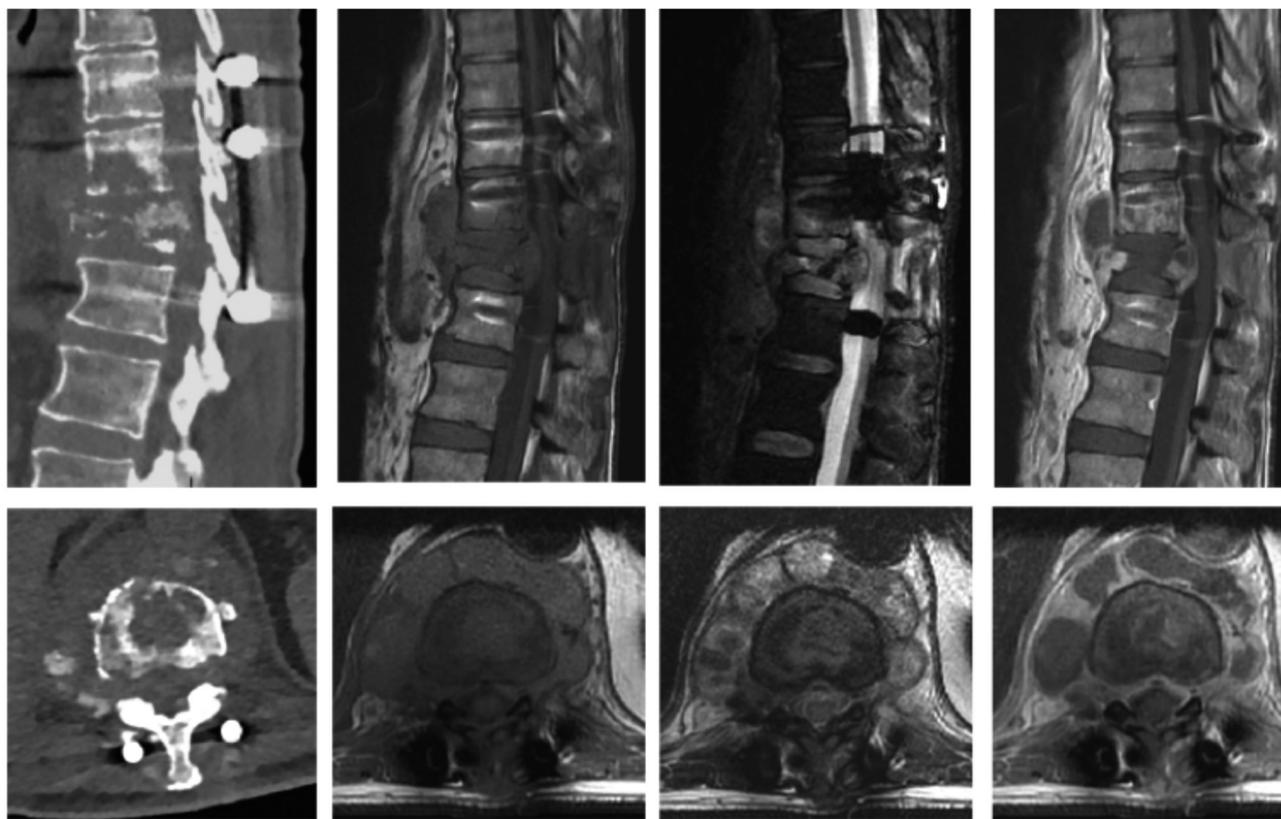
Left panels : sagittal (top) and transverse (bottom) CT scan views of thoracic vertebrae following arthrodesis of T12 for a pathological fracture. Subsequent images : paired sagittal (top) and transverse (bottom) MRI views of the thoraco-lombar region in T1, T2 with suppression of the fat signals and T1 following injection, respectively. Osteolytic destruction of T12 can be observed, with extension of the infection to the surrounding soft tissues and a large epidural leak ; calcifications are best seen on the CT images. Such destruction of a vertebral body, with extension of collections to the surrounding soft tissues, particularly to the anterior paraspinous space, is very suggestive of a tuberculous spondylitis, especially when found in patients of Asian, Oriental or African origin.
